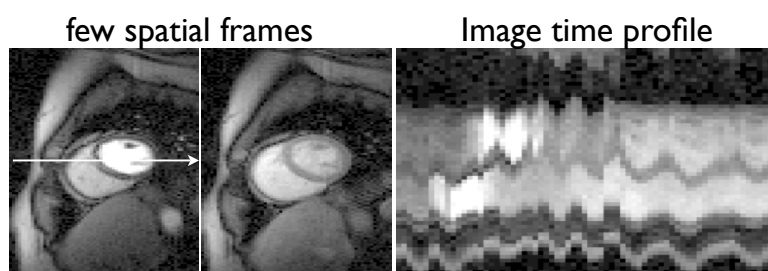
The fully sampled myocardial perfusion MRI dataset used as a ground-ruth during the retrospective undersampling experiments. Note the ripples in the image time profile correspond to large inter-frame motion.
